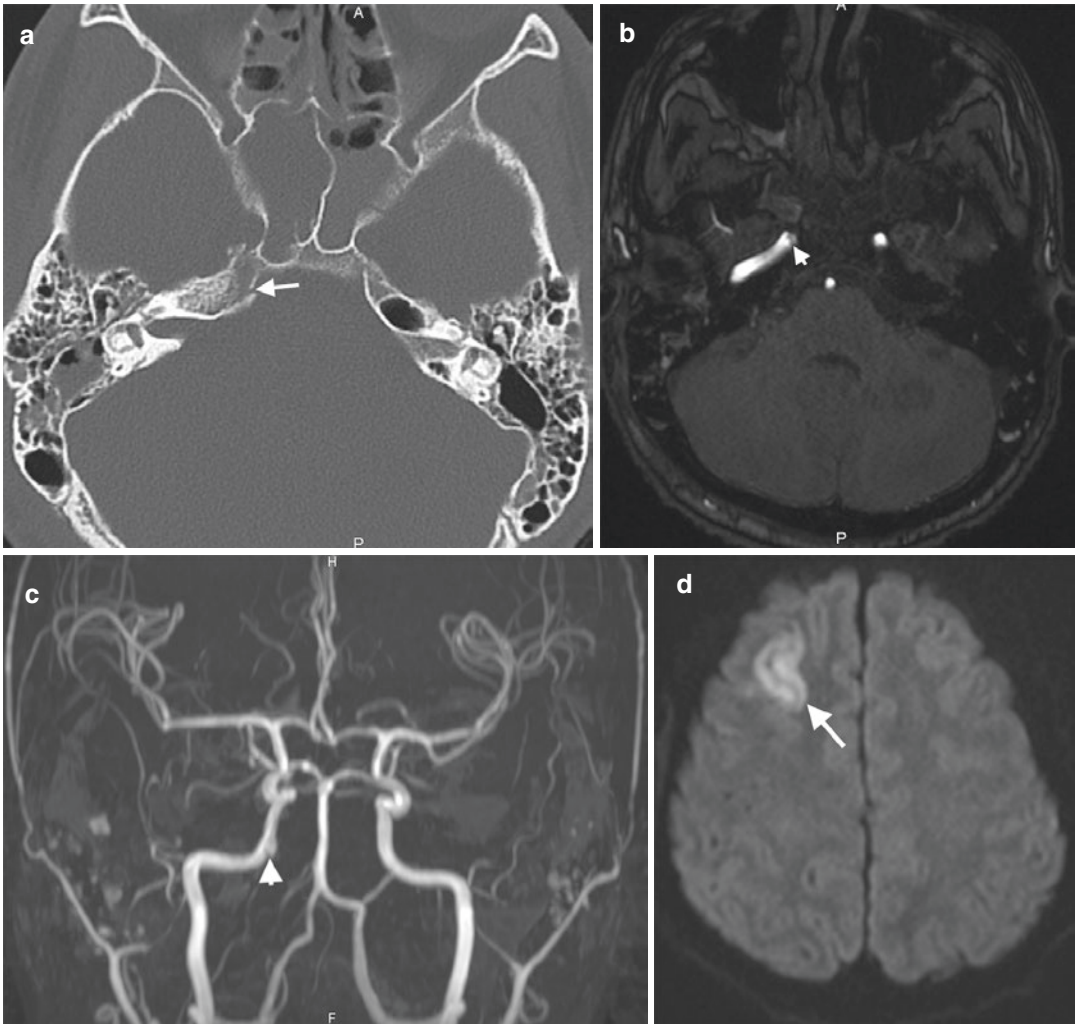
Temporal bone fracture with carotid artery injury in a 17-year-old man with a history of fall. (a) Axial CT image reveals right petrosal ridge fracture (arrow) involving right carotid artery. Axial 2D (b) and 3D (c) TOF MR angiography images show linear hypointense filling
